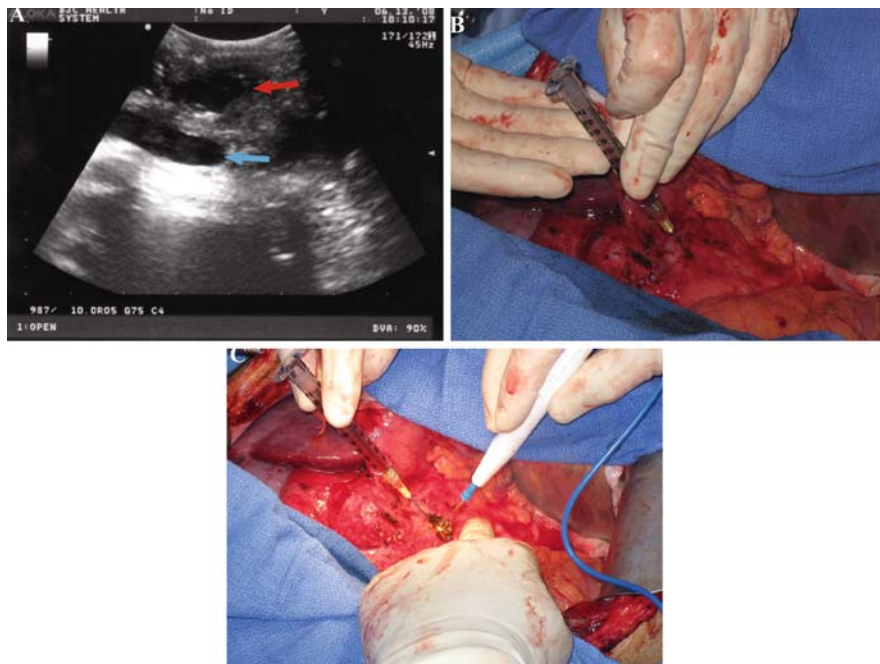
Locating the pancreatic duct using ultrasound guidance and a syringe. (a) The red arrow indicates the dilated pancreatic duct and the blue arrow highlights the superior mesenteric vein. (b) Note the presence of pancreatic ductal hypertension as pancreatic fluid spontaneously decompresses into the syringe. (c) Bovie cautery is used to unroof the pancreatic duct
